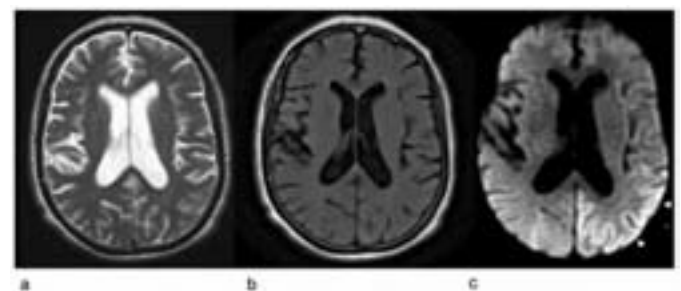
Sporadic Creutzfeldt-Jakob Disease (CJD). (a) T2 weighted image (FSE, TR=6000 msec, TE=106 msec, slice=6 mm) and (b) FLAIR image (FSE, TR=8002 msec, TE=166 msec, slice=6 mm) show mildly prominent ventricles but no other abnormality. (c) Diffusion weighted imaging (EPI, TR=10000 msec, TE=83 msec, B=1000, slice=5 mm) demonstrates cortical high signal intensity in a non-vascular distribution (arrow heads). This is suggestive of sporadic CJD.
